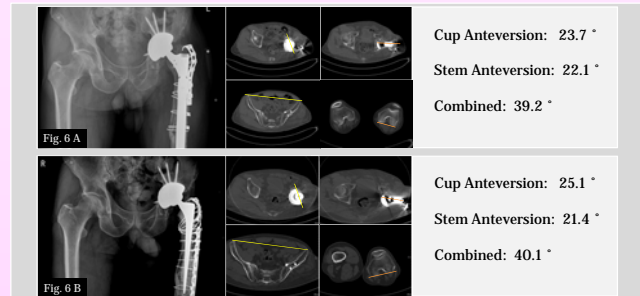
61-year-old male patient; Revision of loosened stem only Preoperative (A) and Postoperative (B) X-ray and CT
